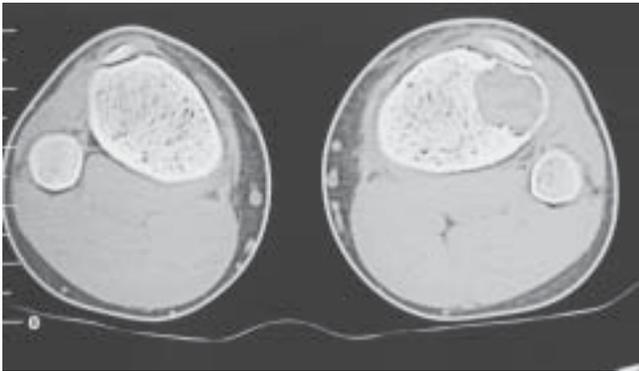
CT scan of the lesion one year after injury.
